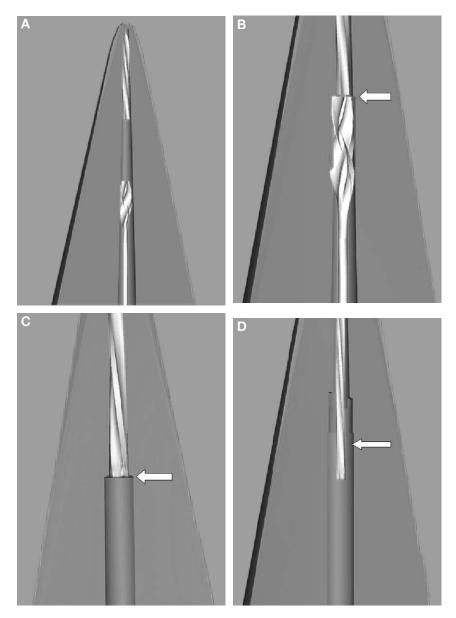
(A) Initially, a small-sized instrument is selected and carried down to the obstruction. (B) Instruments are used sequentially to enlarge the root canal space. The arrow in the figure points toward the approximation of a modified LightSpeed instrument and the root canal obstruction. (C) The arrow in the figure points toward a shelf of dentine that has been created around the separated instrument. (D) The arrow indicates a trough created around the separated instrument with the help of ultrasonic tips.
